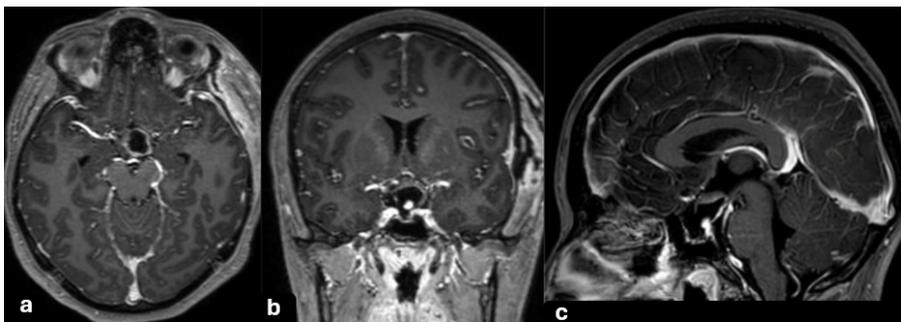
Postoperative magnetic resonance imaging of the brain with contrast in axial (a), coronal (b) and sagittal (c) views. There is evidence of adequate tumor resection with no apparent recurrence or associated collections.
